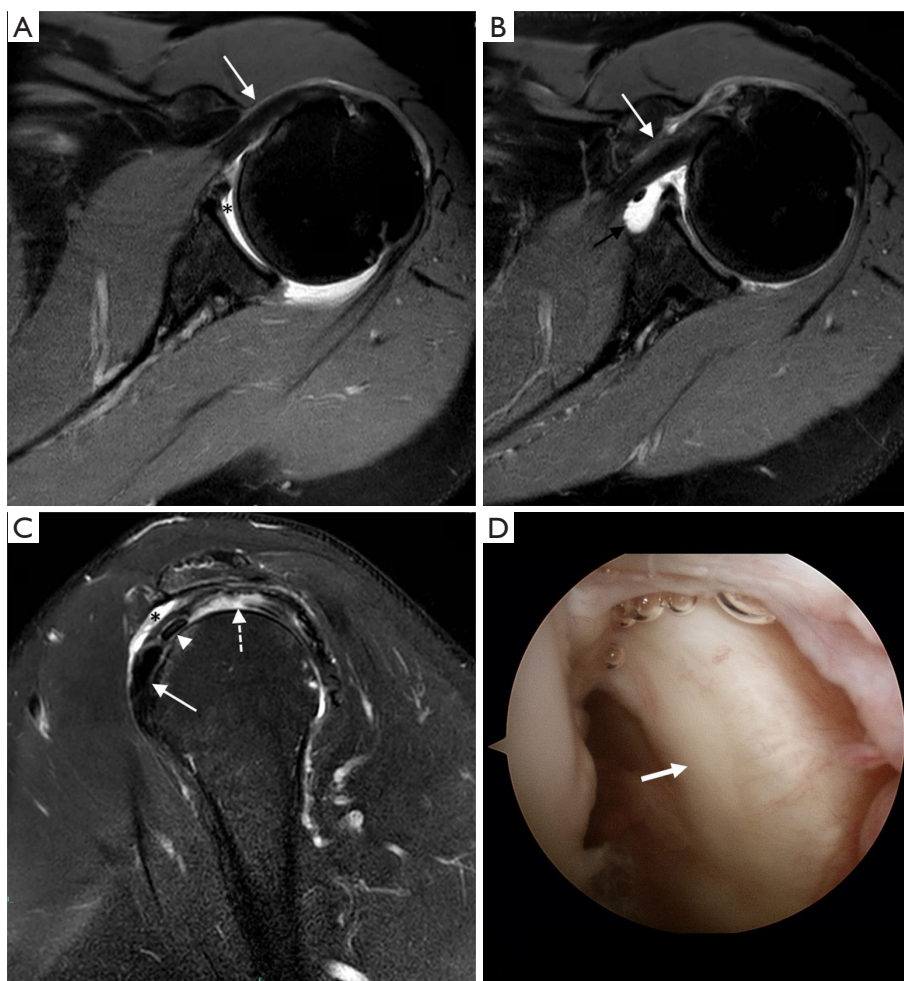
A 63-year-old man with left shoulder pain without subscapularis tendon tear. The shoulder MR images in axial PD/Fs (A) and axial internal rotation PD/Fs (B) show normal course and signal intensity of subscapularis tendon (white arrow) with small amount of joint effusion (asterisk). Minimal fluid in subscapularis bursa is also visualized (black arrow) (B). Sagittal oblique T2W/Fs (C) shows normal subscapularis tendon (white arrow), tendinosis of long head biceps tendon (arrow head) and partial-thickness articular side tear of supraspinatus tendon (dotted arrow) with minimal fluid in subdeltoid bursa (asterisk). (D) Arthroscopy revealed normal appearance of the subscapularis tendon (white arrow). MR, magnetic resonance; PD/Fs, fat-suppressed proton density; T2W/Fs, fat-suppressed T2 weighted.
